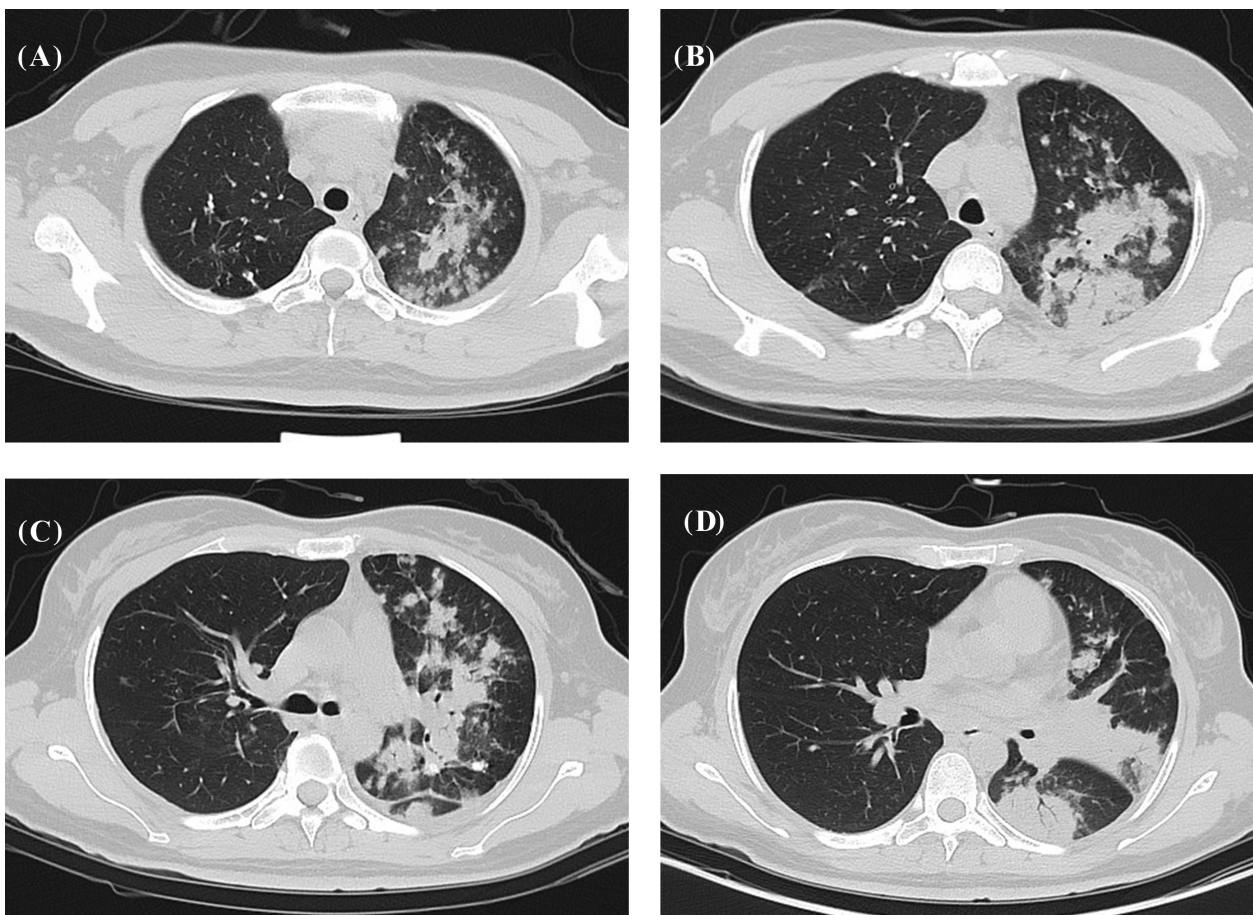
Computed tomography of the thorax after bronchoalveolar lavage. (A–D) Large area of consolidation and patchy shadows in the upper and lower dorsal segments of the left lung.
